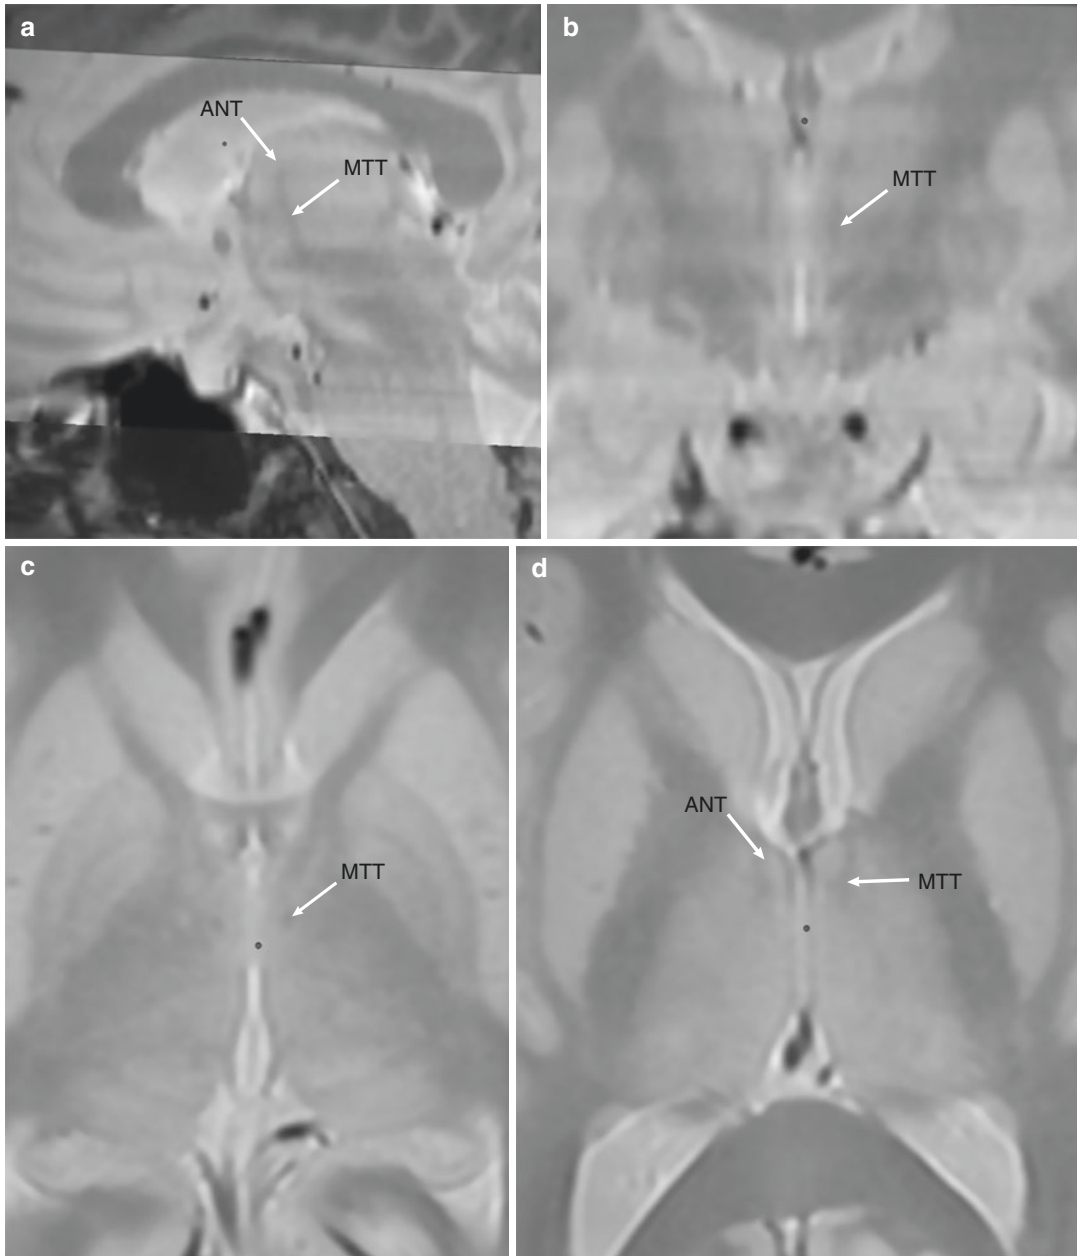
Proton density magnetic resonance imaging sequence obtained on a GE 3-Tesla scanner showing sagittal (a), coronal (b), and axial (c) images of the mammillothalamic tract (MTT), which extends from the mammillary bodies to the anterior nucleus of the thalamus
